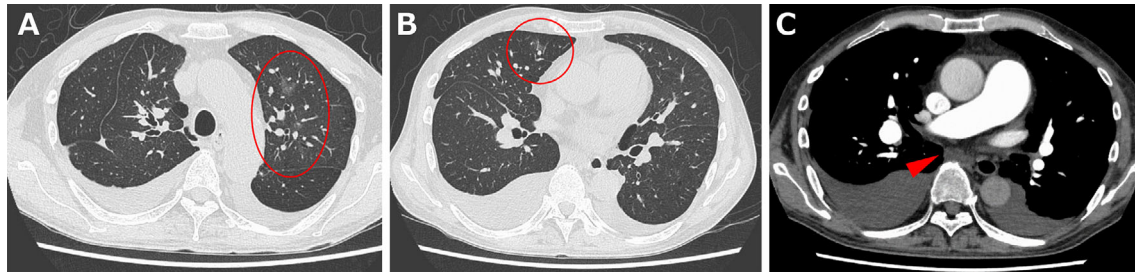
Chest computed tomography findings. A, B: Ground-glass opacities (round), lobar septal wall thickening, and bilateral pleural effusions are observed in the lung window. C: Mildly enlarged mediastinal lymph nodes (arrowhead) and dilated pulmonary arteries are observed in the mediastinal window.
